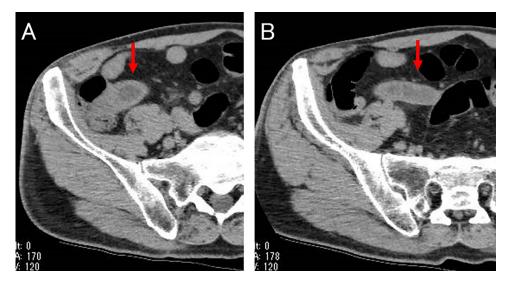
Abdominal computed tomography. Abdominal plain computed tomography showed diffuse appendiceal enlargement and diffuse wall thickening of the entire appendix wall, and the fatty tissue around the appendix was focally thickened (A, B, red arrows).
